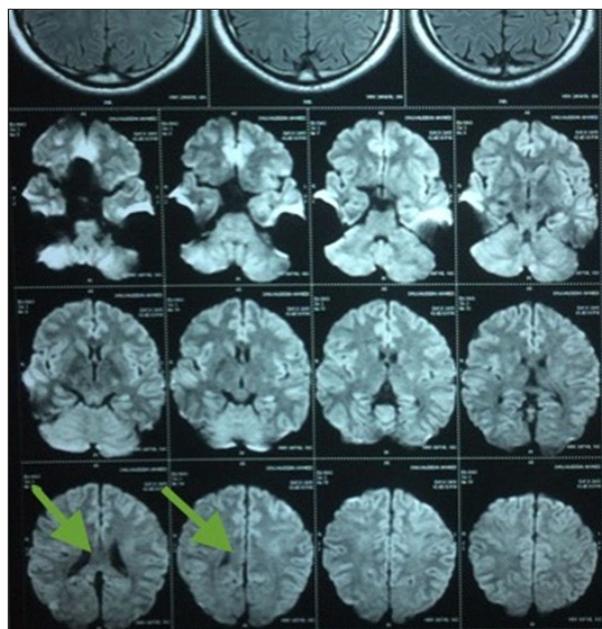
Follow-up MRI at six weeks showing complete resolution of splenial hyperintensity, previously seen in DW images.
